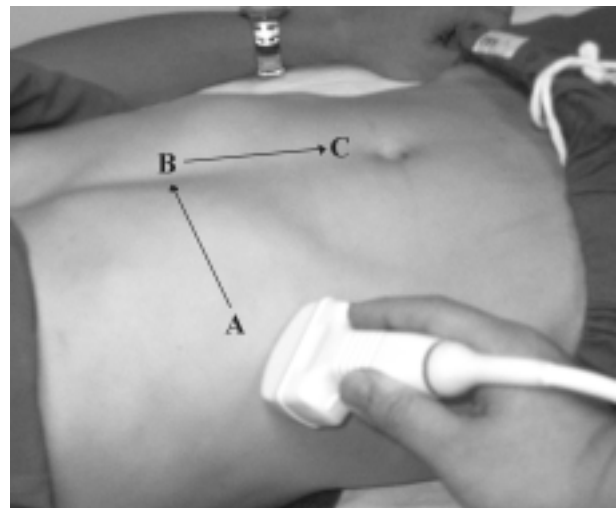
Three standard positions in the UHP ultrasound protocol suggested by Rose et al.¹⁴ A: Hepatorenal view; B: Transverse subxiphoid cardiac view; and C: Transverse aortic view.
